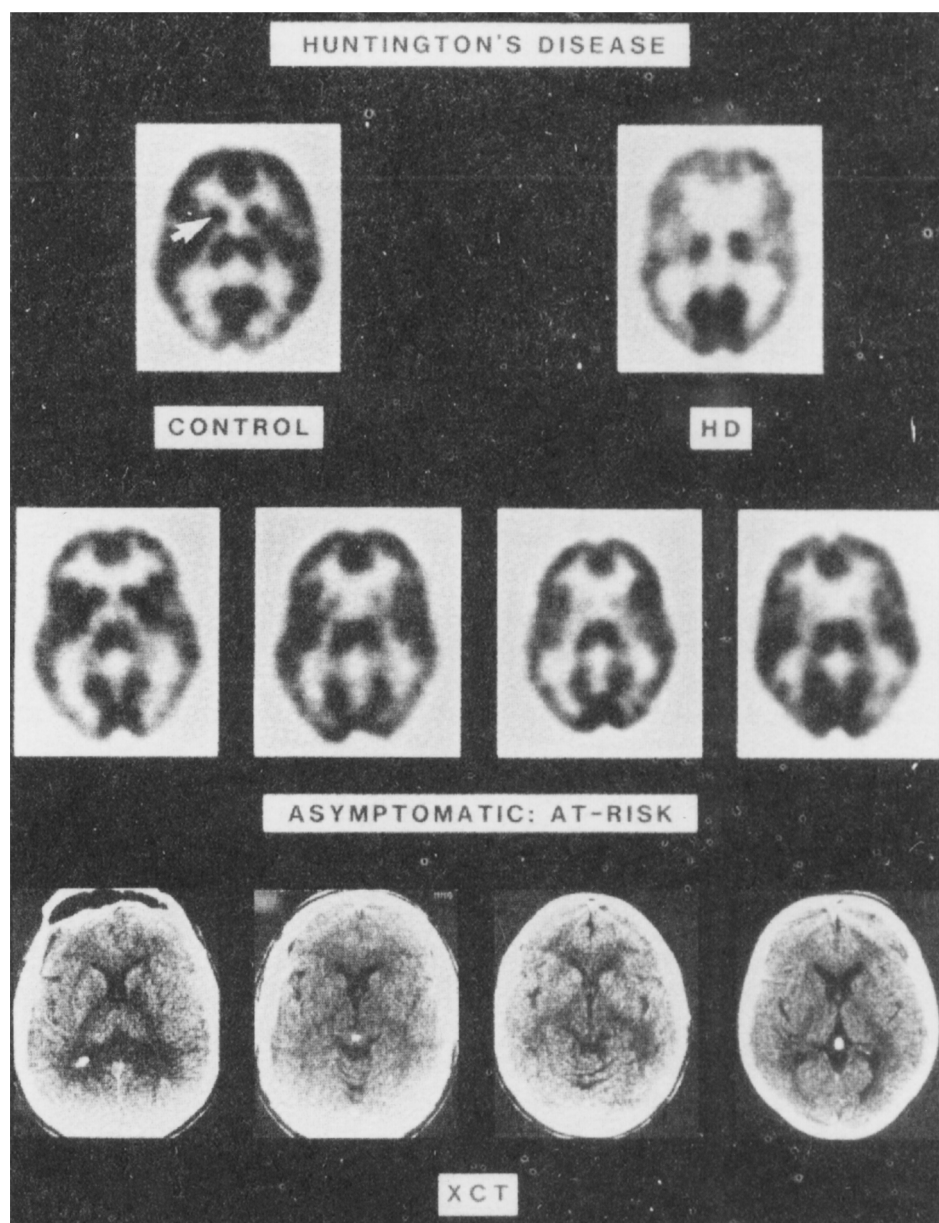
Glucose metabolism in a control subject (upper left), in a patient with HD (upper right) and in 4 asymptomatic at-risk individuals (middle row). The 4 subjects show degrees of metabolic patterns in the caudate, from normal (leftmost) to severely hypometabolic (rightmost). CT scans were normals in all 4 of these asymptomatic at-risk subjects (bottom row). Reprinted with permission from Mazziotta et al., 1987.
